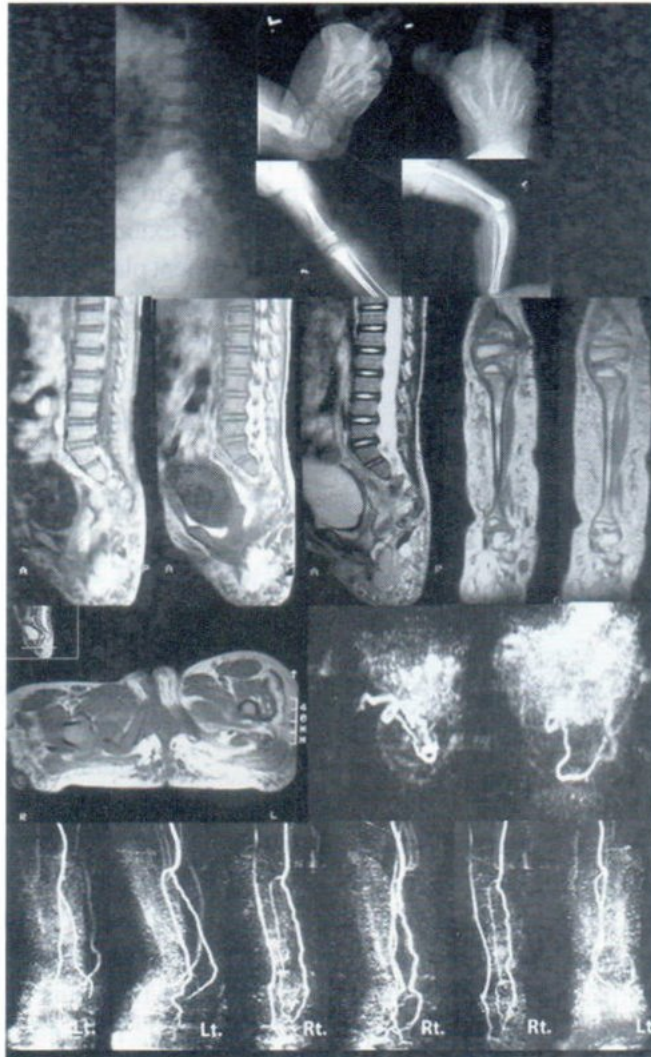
A 7-month-old female patient presented with Lt. leg enlargement, bilateral club feet and both legs hemangioma with occasional subcutaneous bleeding. Plain film of lower back, Lt. leg, Lt. foot, MRI and MRA of both legs showed asymmetry enlarged Lt. leg and deformed Lt. foot with subcutaneous soft tissue enlargement and multiple dilated flow void structures extended from Lt. buttock to Lt. foot. No internal pelvic organ involvement was observed. No arteriovenous fistula was detected. Rt. leg was also affected in a lesser degree.
